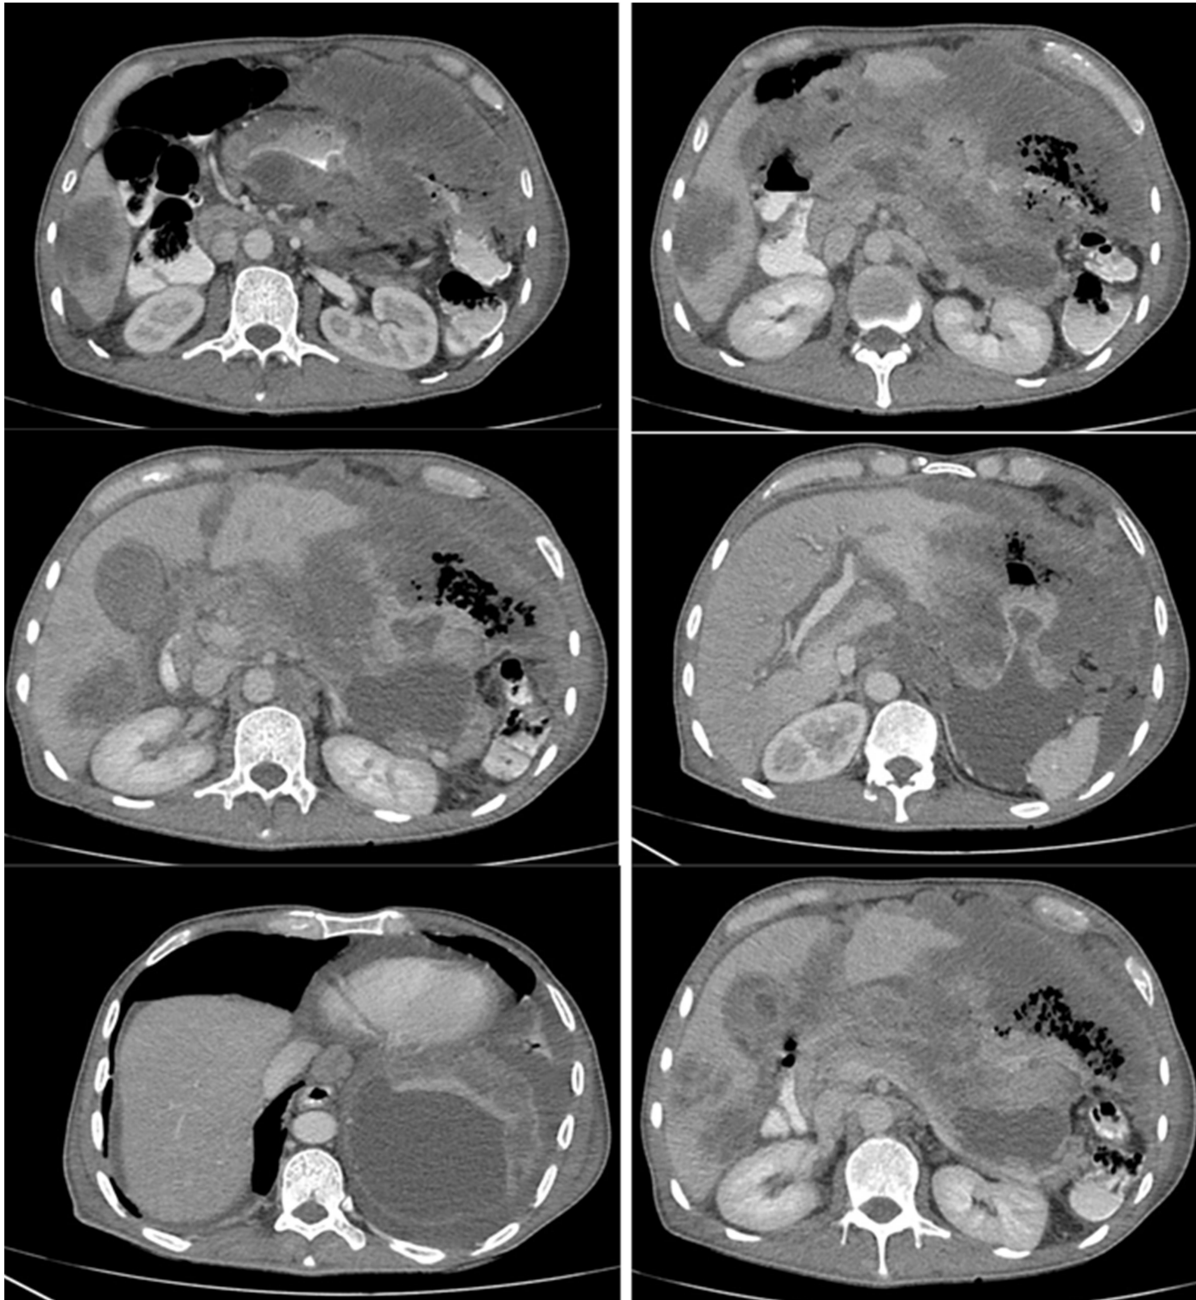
In the triphasic abdominal CT scan with oral contrast. Image A: Infiltration of the greater omentum (Omental Cake). Image B: Infiltration of the lesser omentum. Images C and D: Infiltration of the falciform ligament and gastroduodenal ligament. Image E: Presence of peritoneal carcinomatosis, infiltrating the left hemidiaphragm. Image F: Multiple lesions in the liver parenchyma.
